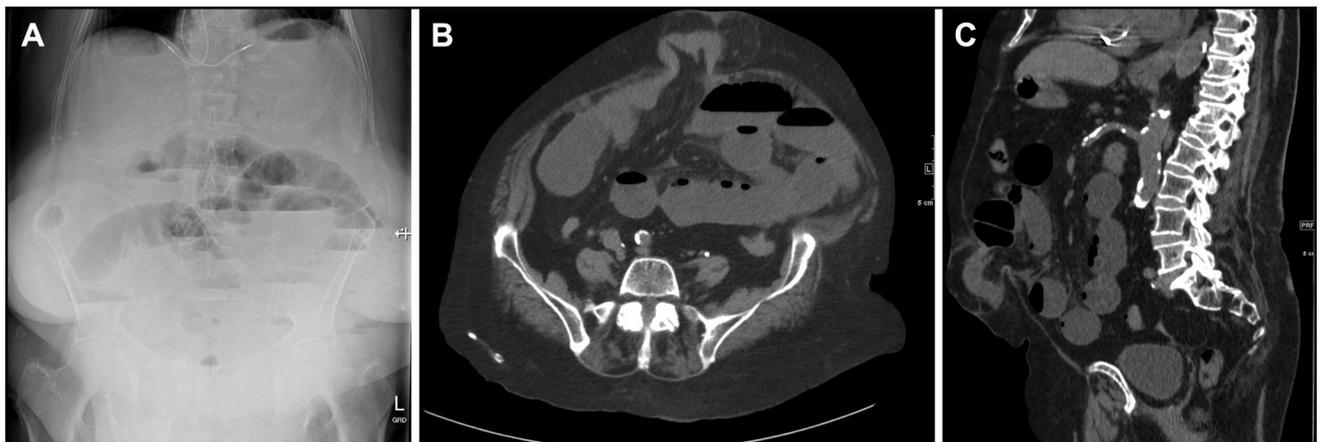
Supine abdominal radiograph (A) and axial and sagittal native computed tomography images (B and C) demonstrate an incarcerated umbilical hernia with obstruction of the small intestine.
